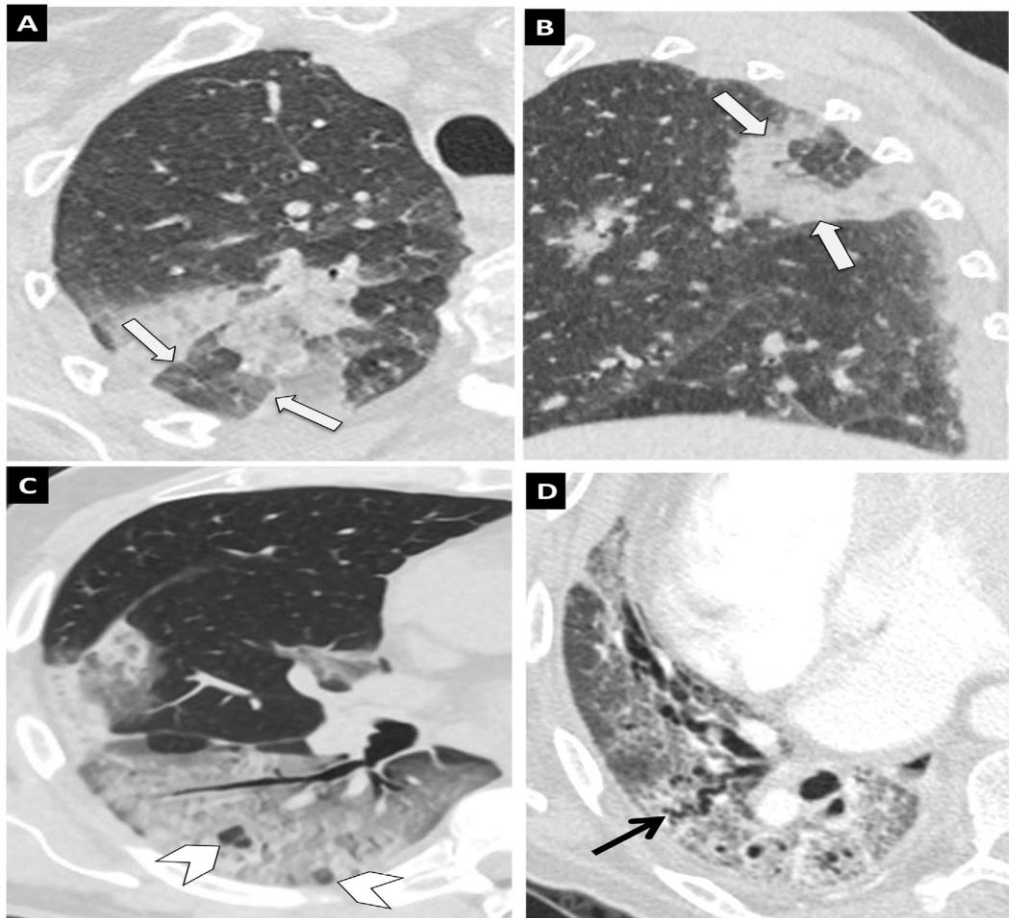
Typical findings in COVID-19 pneumonia on computed tomography (CT). Images from a CT scan of the chest with 1-mm slices [134].
